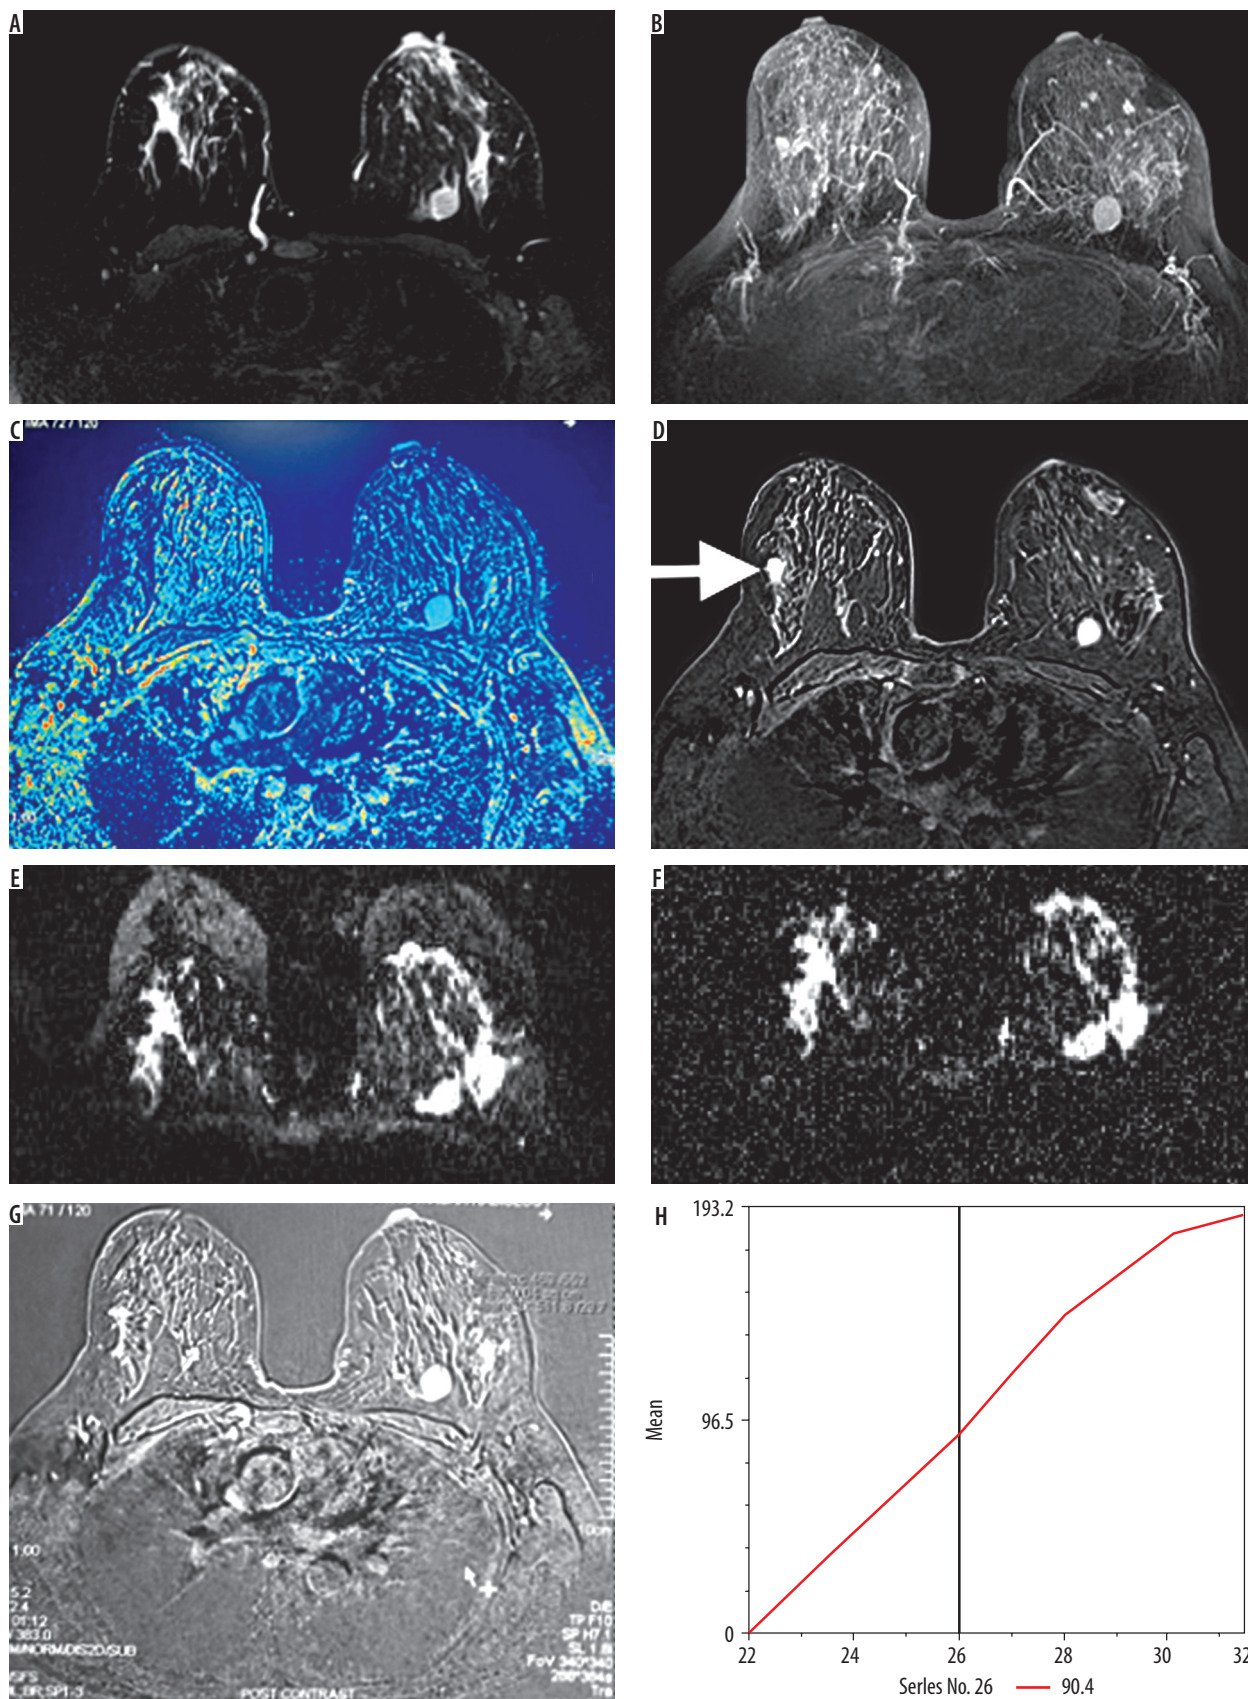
Magnetic resonance imaging breast in the case of fibroadenoma in a 39-year-old woman. A) Axial STIR image of breast showing a well-defined oval hyperintense lesion with smooth margins in the retromammary region of the left breast. B) Maximum intensity projection image showing the smooth margin oval lesion. C) Wash-in colour map maximum intensity projection image showing the smooth margin oval lesion. D) Fat sat T1WI post contrast axial image showing homogenous contrast enhancement of the lesion in the left breast. There is another well-defined fibroadenoma seen in the right breast (arrow). E) Axial diffusion weighted imaging showing hyperintense signals in the mass with F) corresponding high apparent diffusion coefficient value. G-H) Time signal intensity curve of the mass showed type I kinetic curve (persistent enhancement in the delayed phase)
